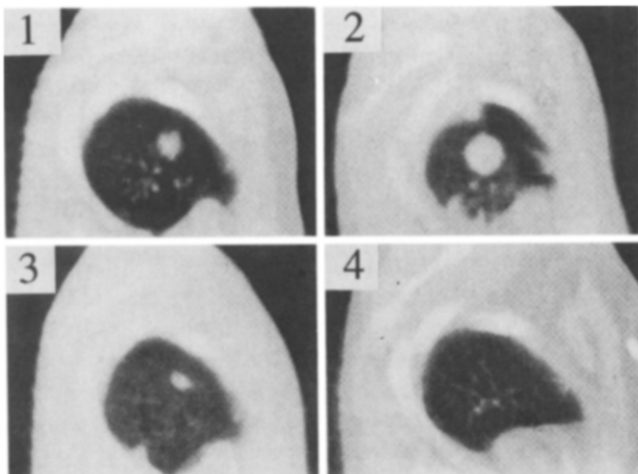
Computed tomography (CT) scan of chest of post-transplant patient; (1) at the time of diagnosis of EBV-LPD; (2) 2 weeks later at the time of infusion of 10^6 donor T cells/kg body weight; (3) 6 weeks after infusion. (4) Subsequent CT scans were reported as normal.
